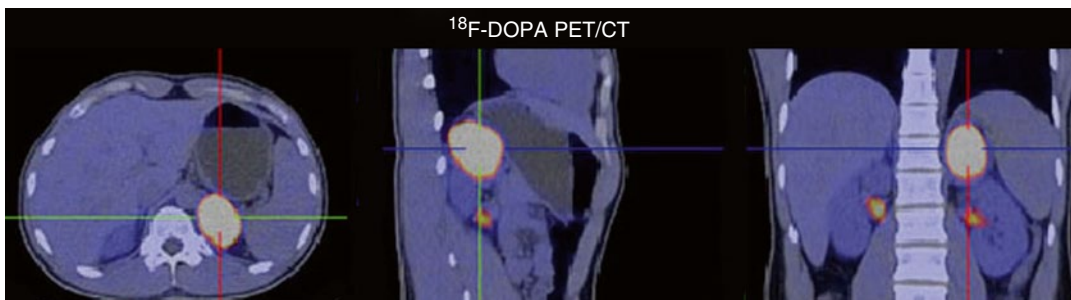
^{18}F -DOPA PET/CT of a pheochromocytoma of the left adrenal gland
